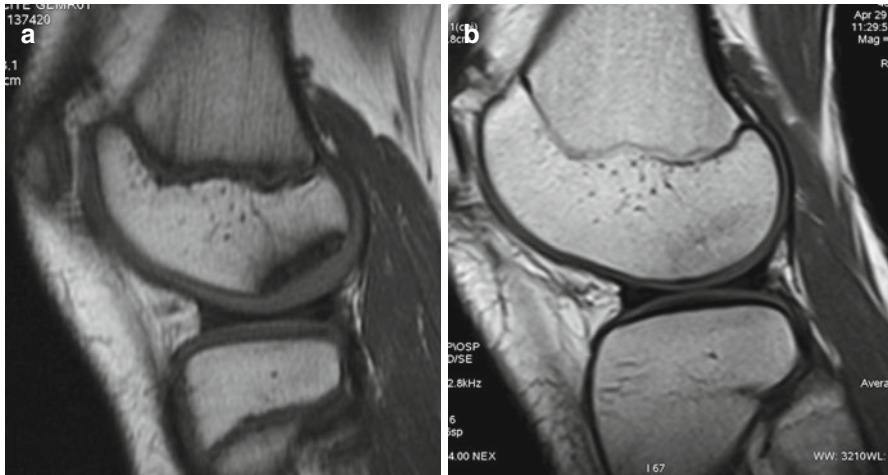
MRI on sagittal plane before and after conservative treatment. (a) A diffuse cartilage thickening with a lunate subchondral suffering area on the lateral aspect of the femoral condyle, without cartilage lesion, is evident. (b) MRI examination performed after 5 years shows a complete restoration of bone integrity
